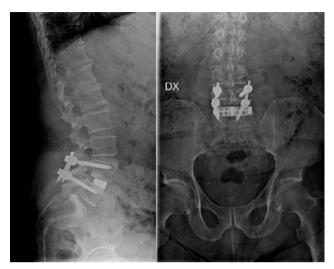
Postoperative lateral and frontal standing X-ray.
